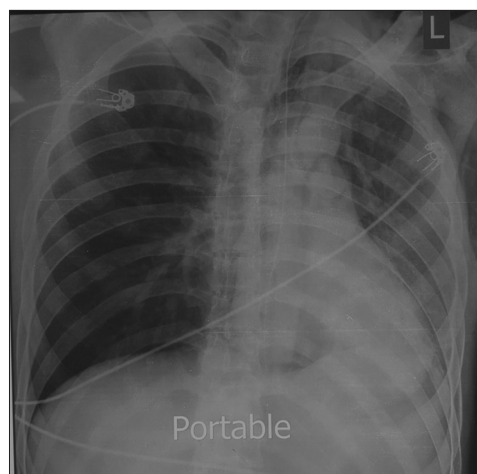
Chest radiography: with left-sided pneumothorax and left lung upper lobe atelectasis on the 6th day of admission
